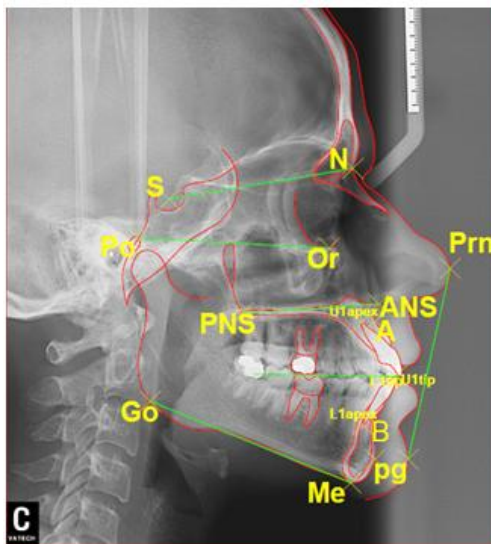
Reference planes on cephalometric radiograph
